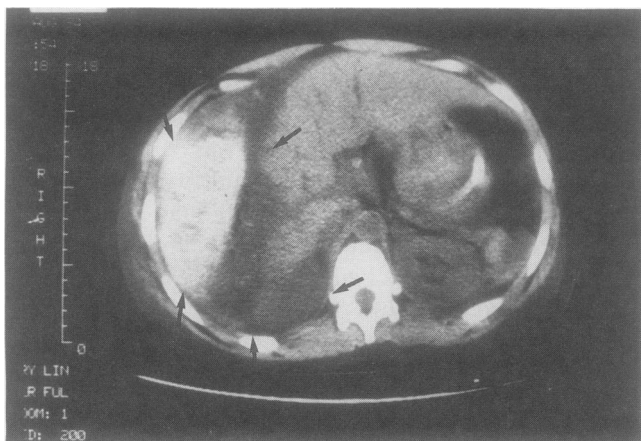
Computed tomography scan with intravenous contrast. Arrows show large hematoma and hemorrhage within the right lobe of liver.
